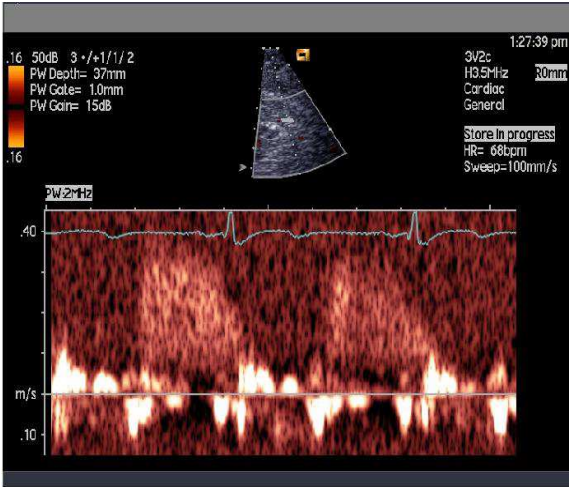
Pulsed-wave Doppler of LAD blood velocity with dominant, easy to trace diastolic component
